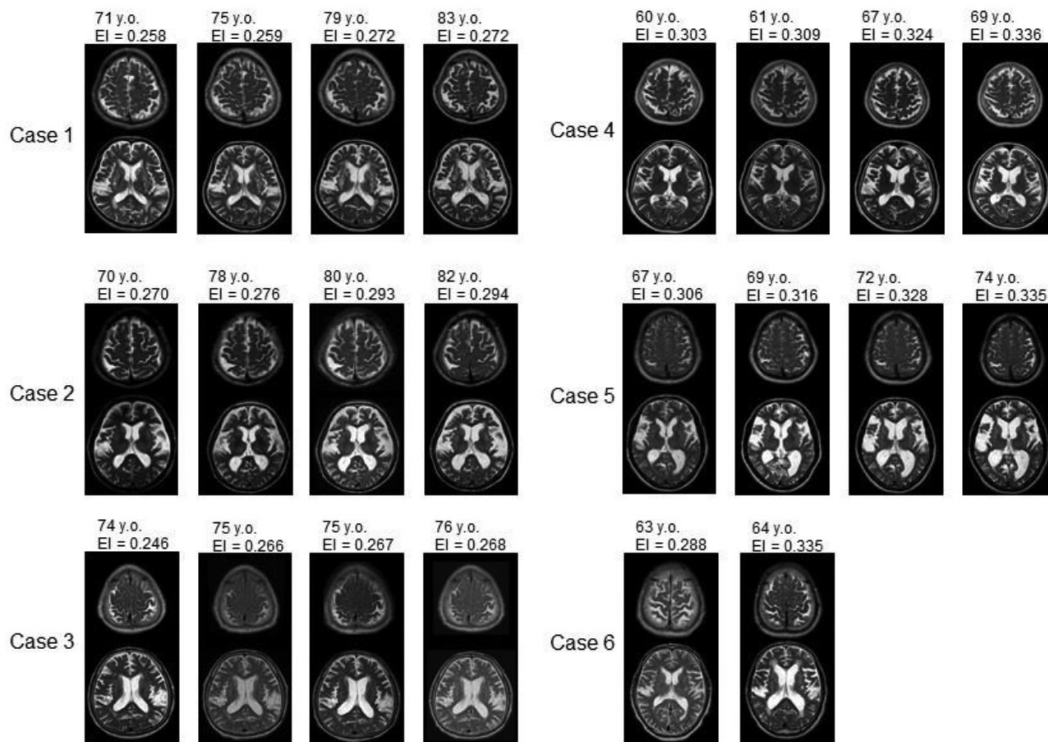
Brain MRI findings of six cases with morphological changes over time. Case 1 had TMC at 71 years of age, with progressive enlargement of the anterior horns of the lateral ventricles. Cases 2 and 3 had TMC at first MRI examination, with progressive enlargement of the anterior horns of the lateral ventricles and Sylvian fissures. Case 3 showed only a small increase in the Sylvian fissures, although the right Sylvian fissure was enlarged at 74 and 75 years of age. Case 4 had TMC and ventriculomegaly at first examination, with progressive enlargement of the Sylvian fissures. Case 5 already exhibited DESH findings at first MRI examination, but showed progressive enlargement of the anterior horns. Case 6 developed sudden DESH findings at 20 months from the first scan (at 63 years of age).
